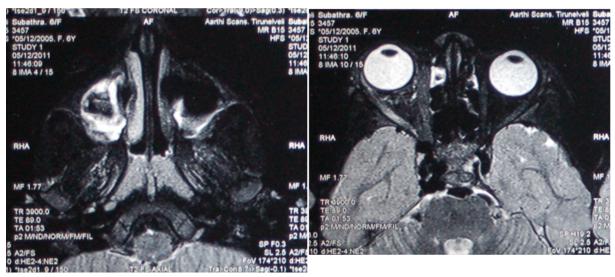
MRI showing exophthalmos in right eye and dilatation of superior ophthalmic vein.
